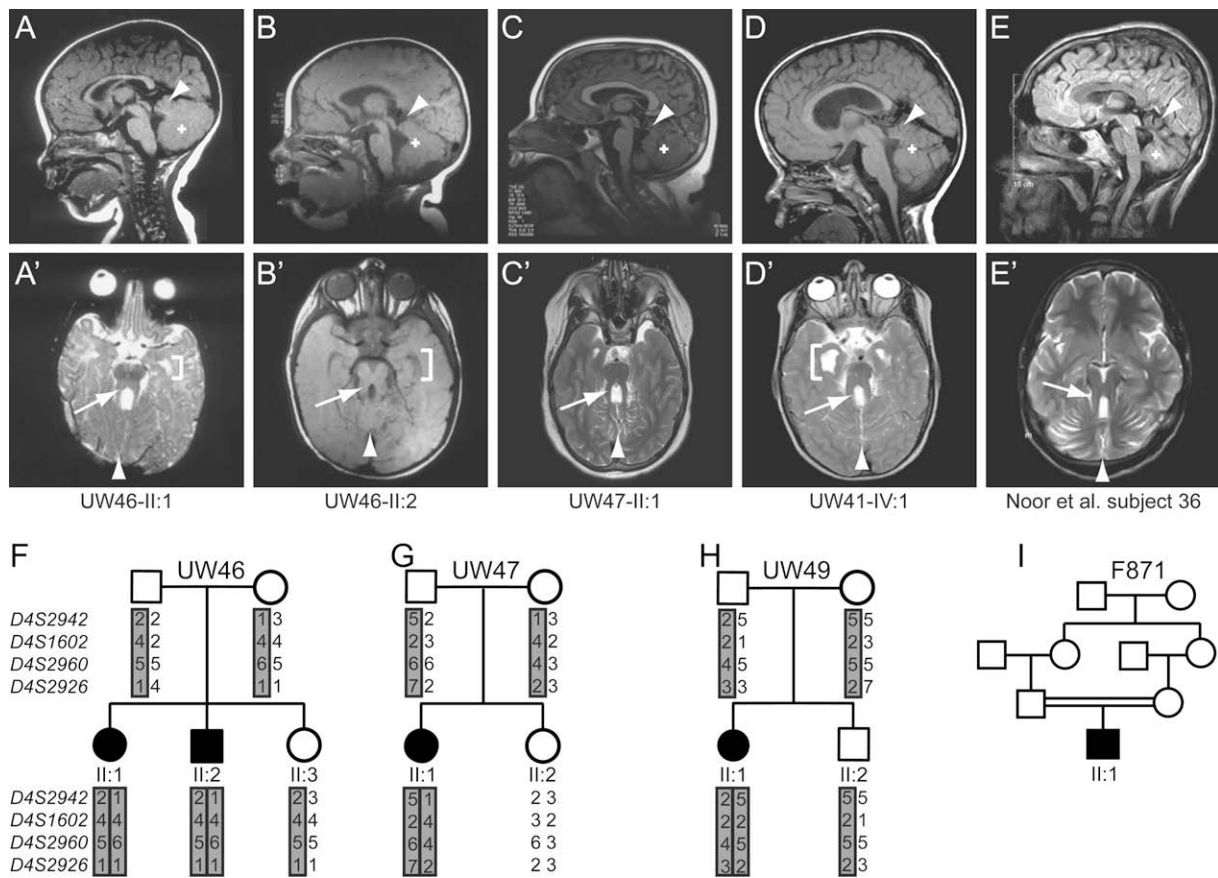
Segregation Analysis and MRI Images in Additional Families with *CC2D2A* Mutations
